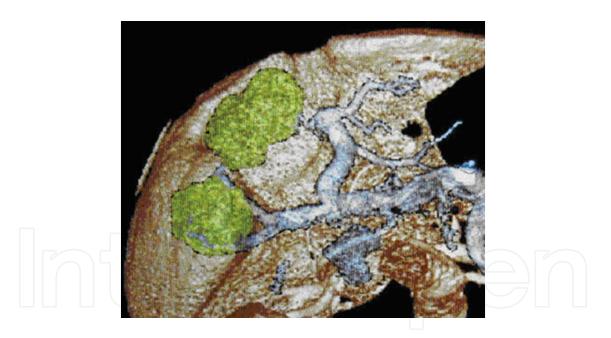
Computed tomography 3-D reconstruction before surgical showing liver metastases (http://c2i2.digithala-mus.com/winter2003/Imaging%20update%20in%20metastatic%20liver%20disease.asp).
